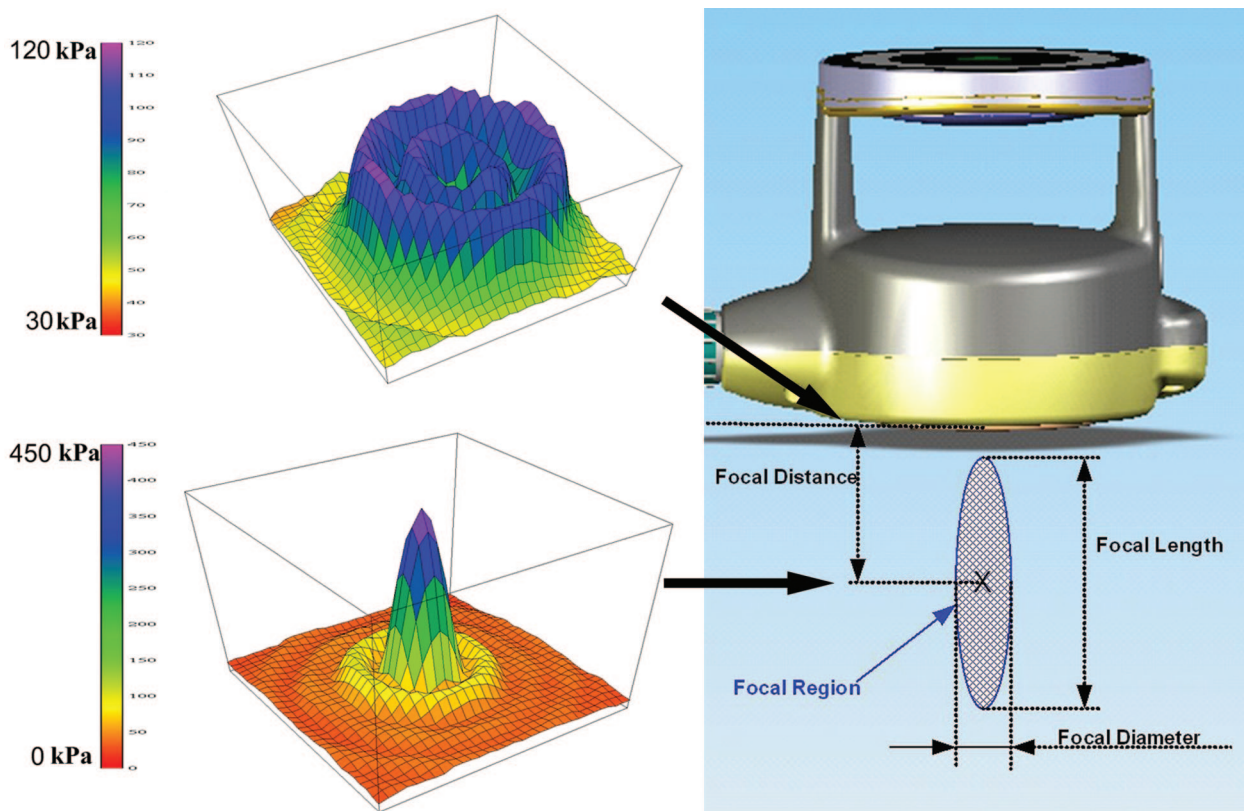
Acoustic field distribution of the focused ultrasound energy. The focal distance was defined as the distance between the transducer surface and the focal point (14 mm), whereas the focal point is the point in which the pressure level is maximum (the "X" in the center of the focal length).
